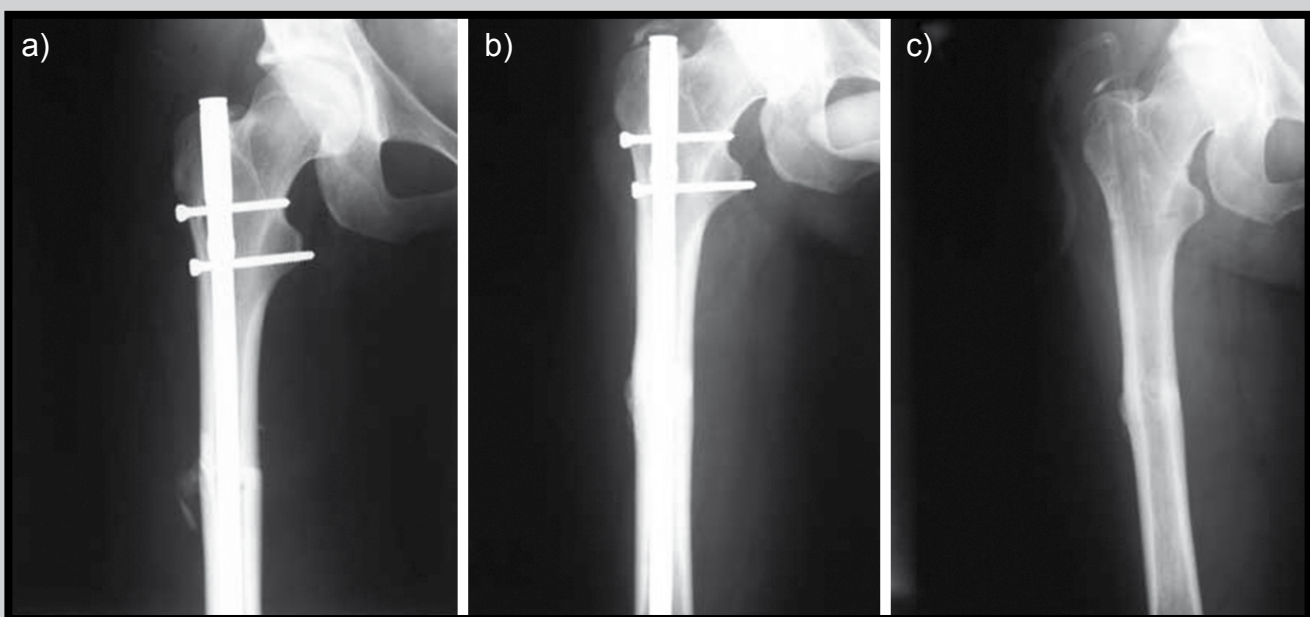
X-Ray photos taken after: a) inserting the implant, b) two years after inserting the implant, c) two and a half years after removing the implant.
